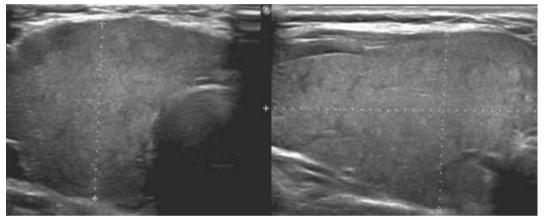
Ultrasound image showing diffusely bulky thyroid gland with no focal lesion-Goitre pattern.
